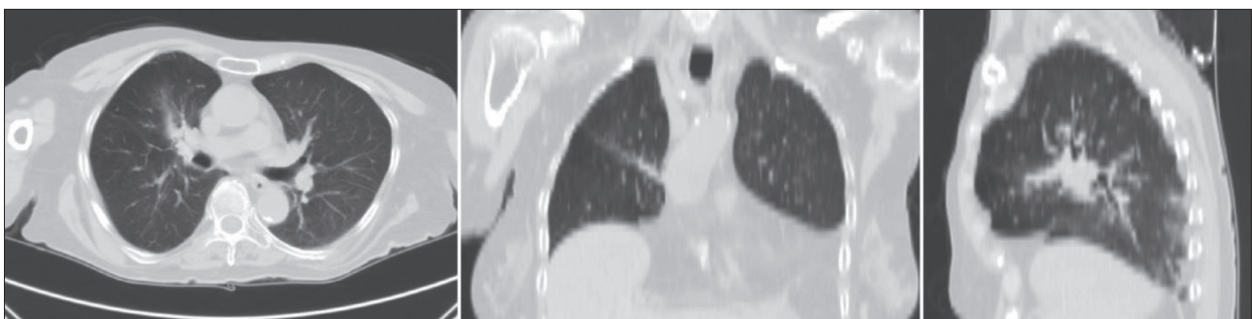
Chest CT after 12 months of treatment with osimertinib
